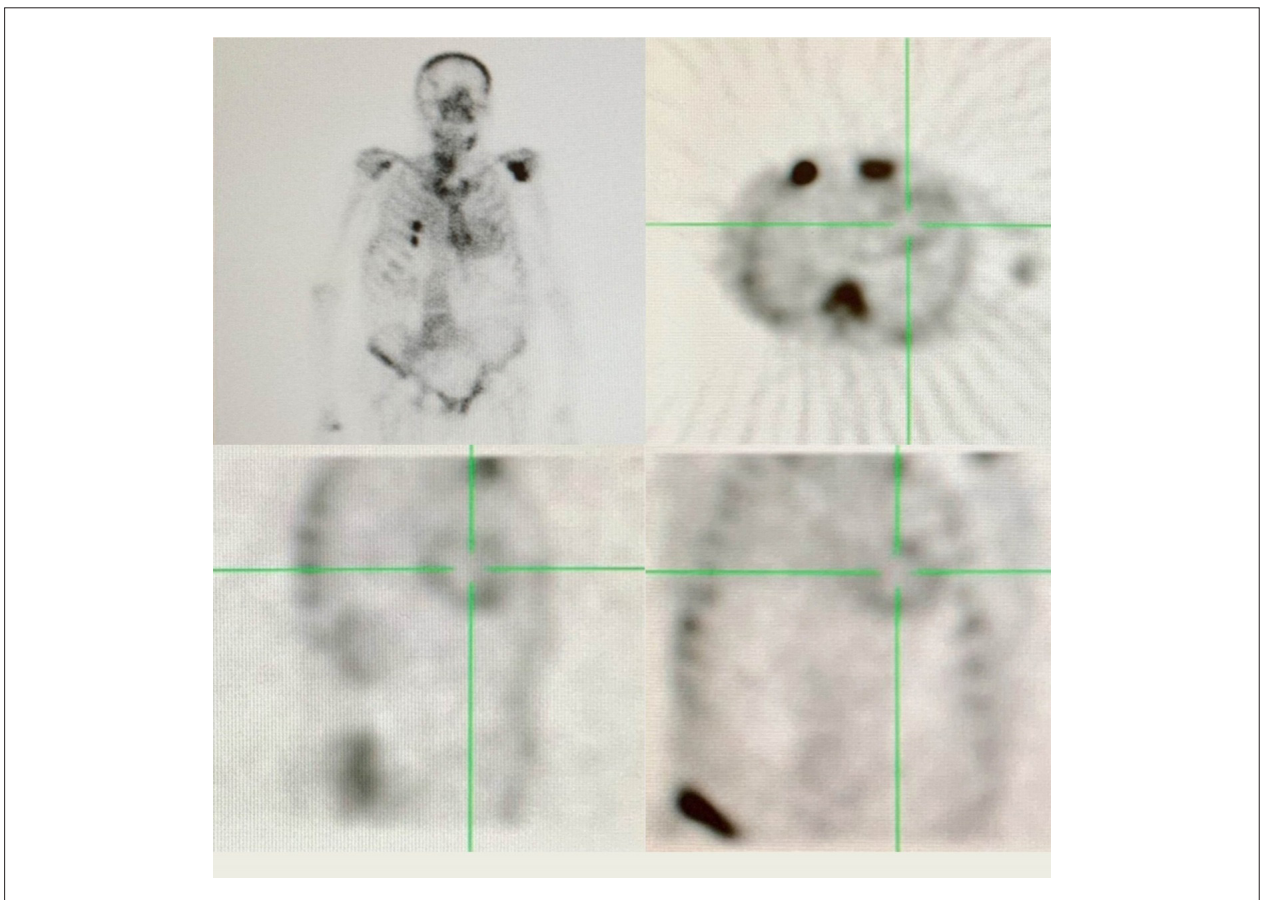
^{99m}Tc-DPD scintigraphy showing grade II biventricular tracer uptake.
